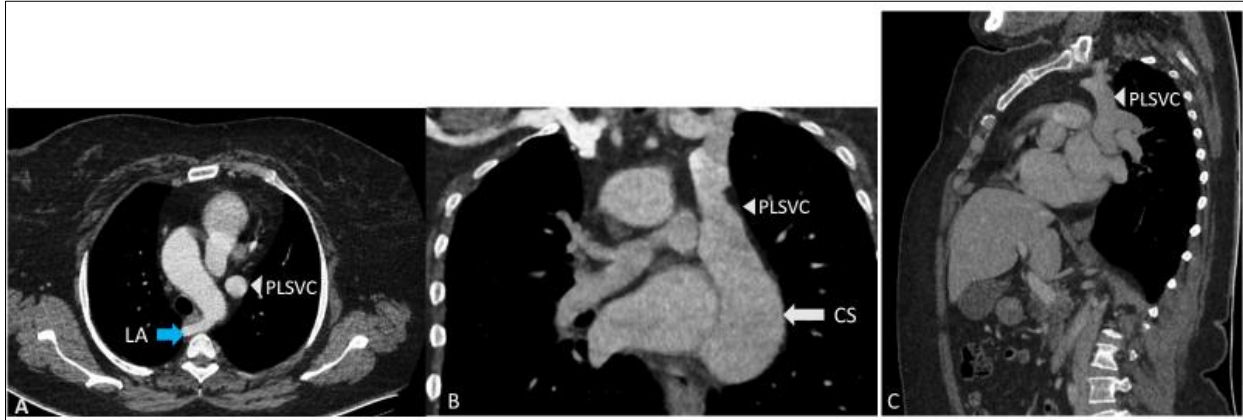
Axial (A), coronal (B), and oblique sagittal (C) CT images showing a persistent left superior vena cava (arrowhead) draining into a dilated coronary sinus (white arrow), with an arteria lusoria (blue arrow). PLSVC = persistent left superior vena cava; CS = coronary sinus; LA = arteria lusoria
